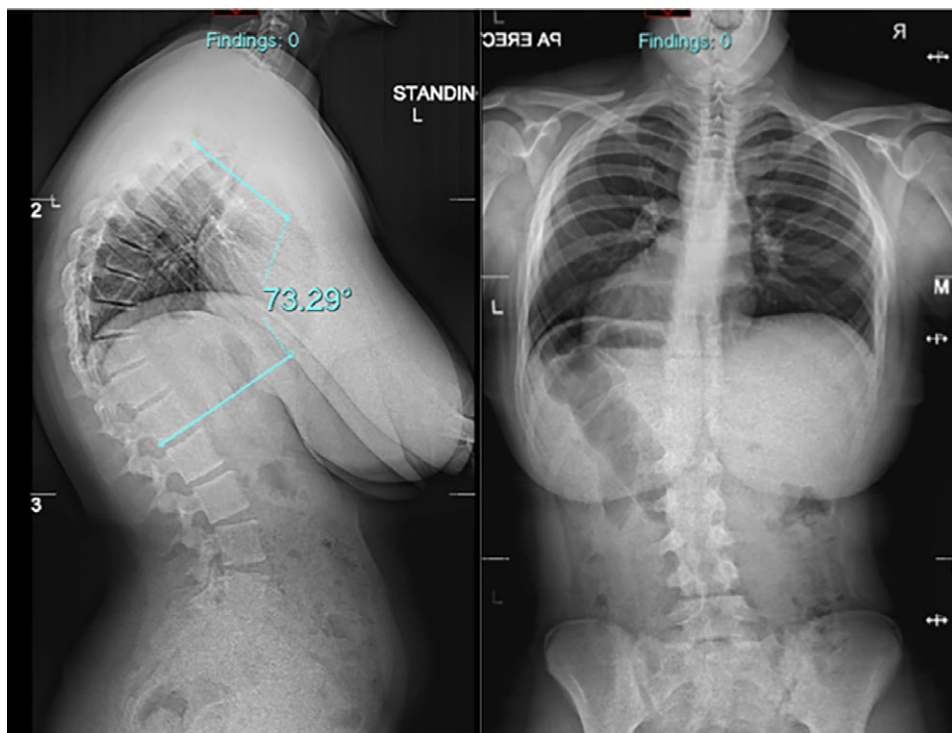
Whole spine PA and lateral radiographs
